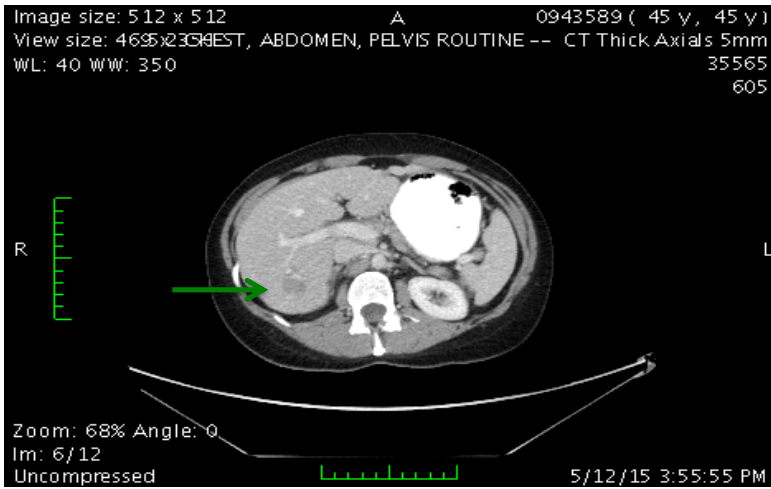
CT scan of abdomen & pelvis - May 2015
